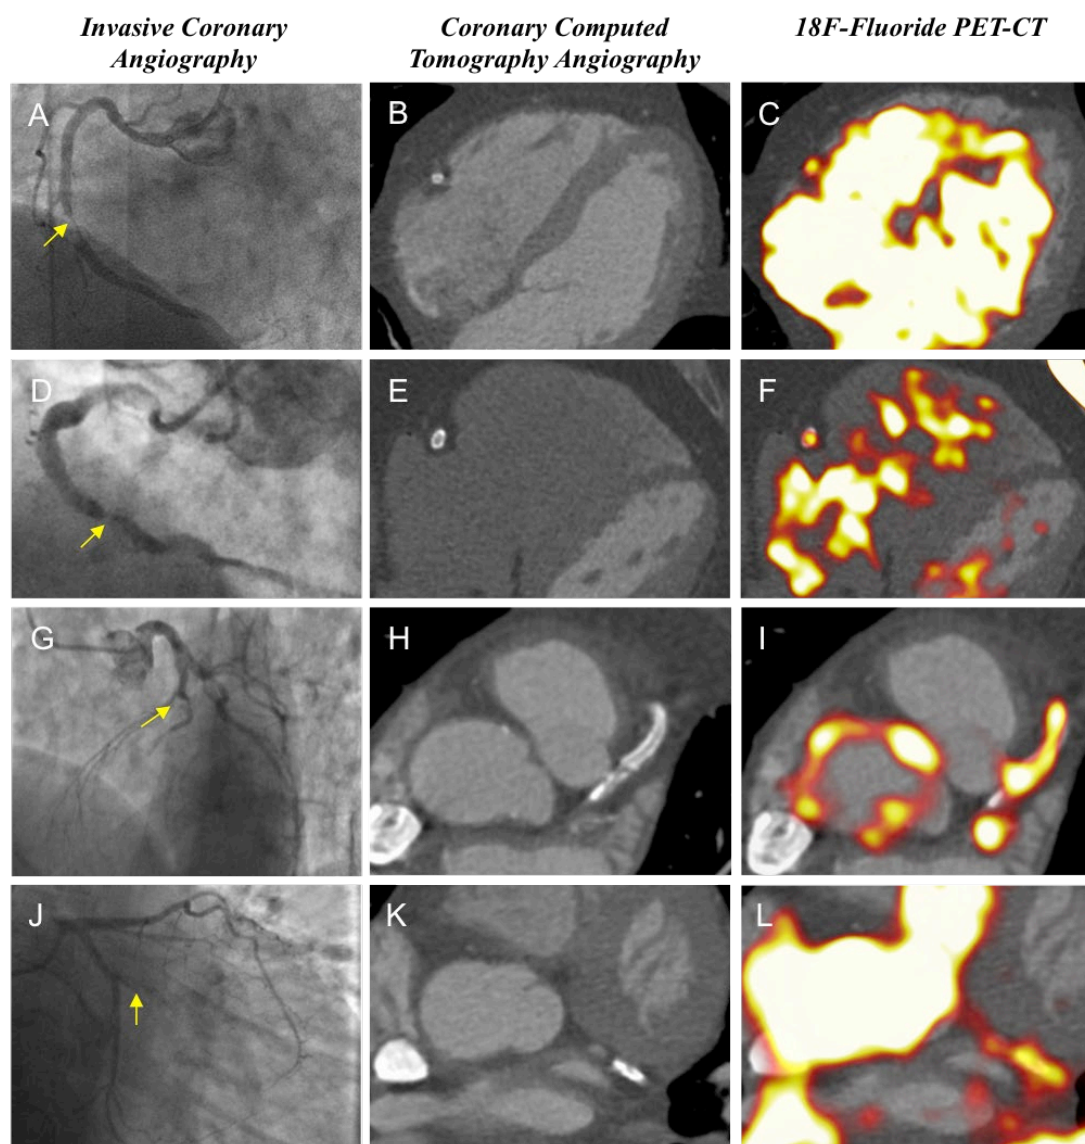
Culprit plaque ¹⁸F-fluoride activity on positron emission tomography-coronary computed tomography angiography.
